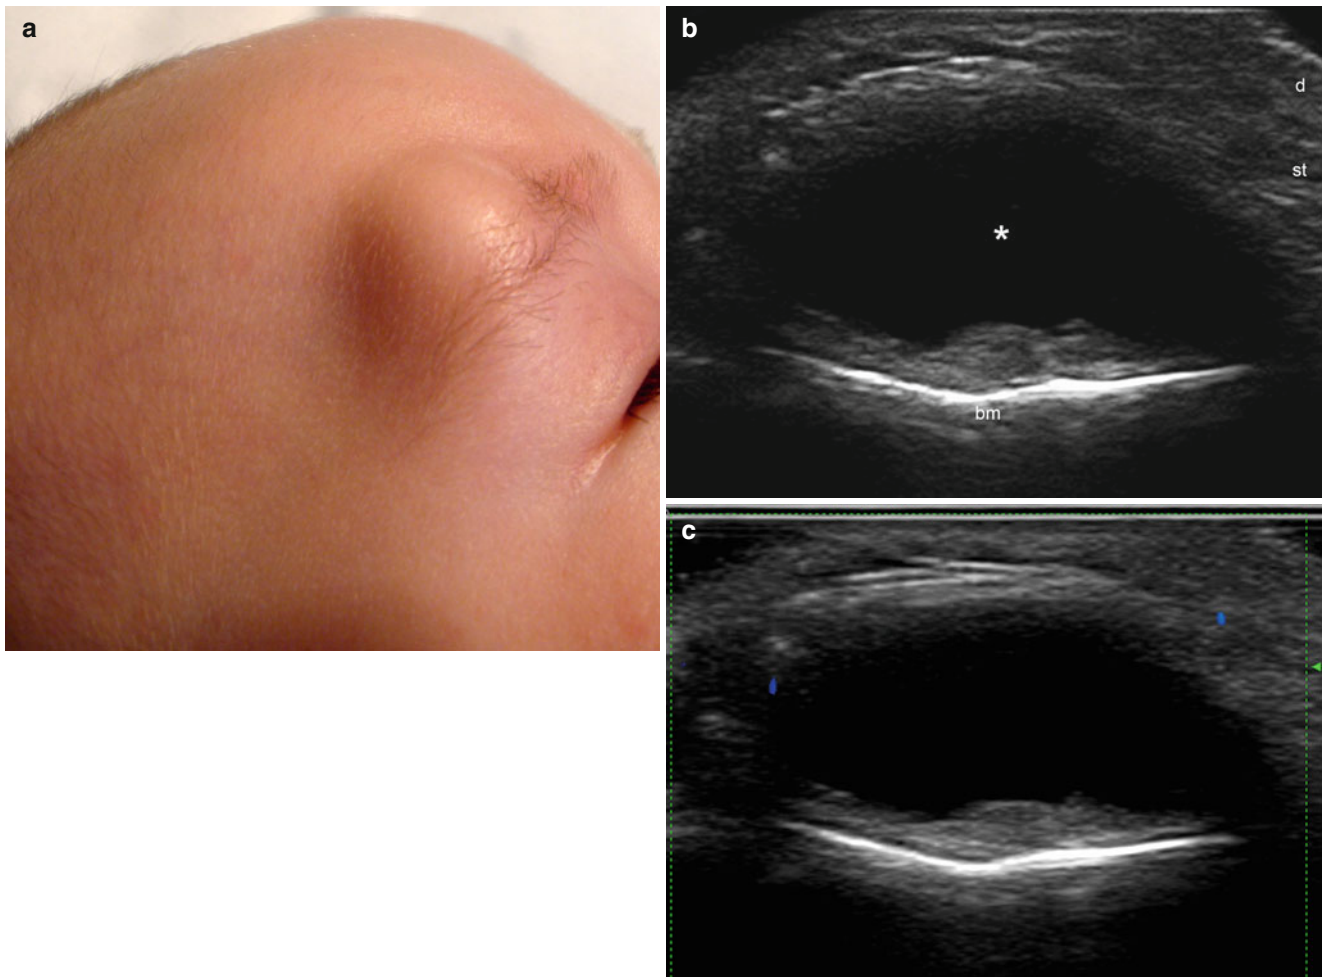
(a–c) Dermoid cyst. (a) Clinical image shows a skin-colored swelling in the right eyebrow. (b) Grey scale ultrasound image (transverse view) demonstrates a well-defined, oval-shaped anechoic structure with a thick hypoechoic posterior wall located in the deep
